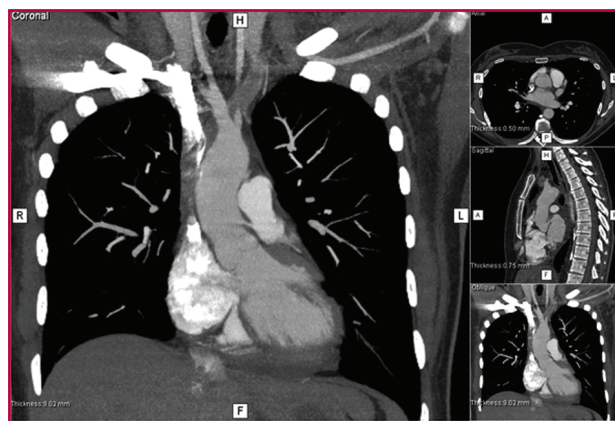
Contrast-enhanced multi-detector row chest computed tomography. A complete obstruction of the proximal superior vena cava is observed, with a filling defect suggestive of luminal thrombus.
